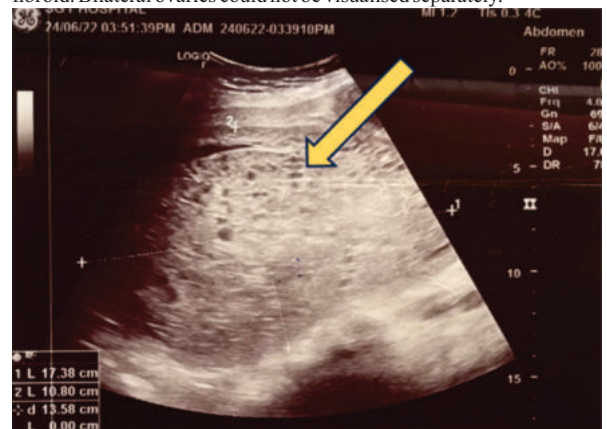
The ultrasonography image depicting a heterogeneous mass (arrow) measuring 17.3 x 10.8 x 13.58 cm, with multiple diffusely scattered cystic spaces.
